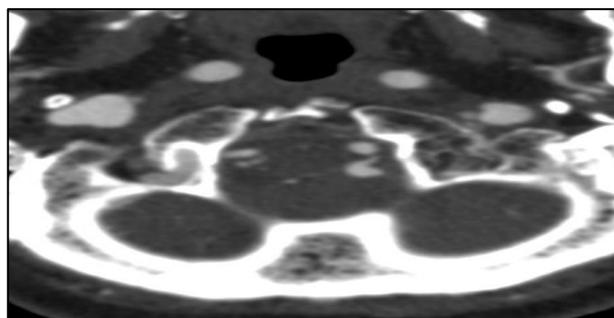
Axial contrast CT angiography MIP image showing well-defined out pouching arising from the posterior inferior cerebellar artery - s/o aneurysm.
